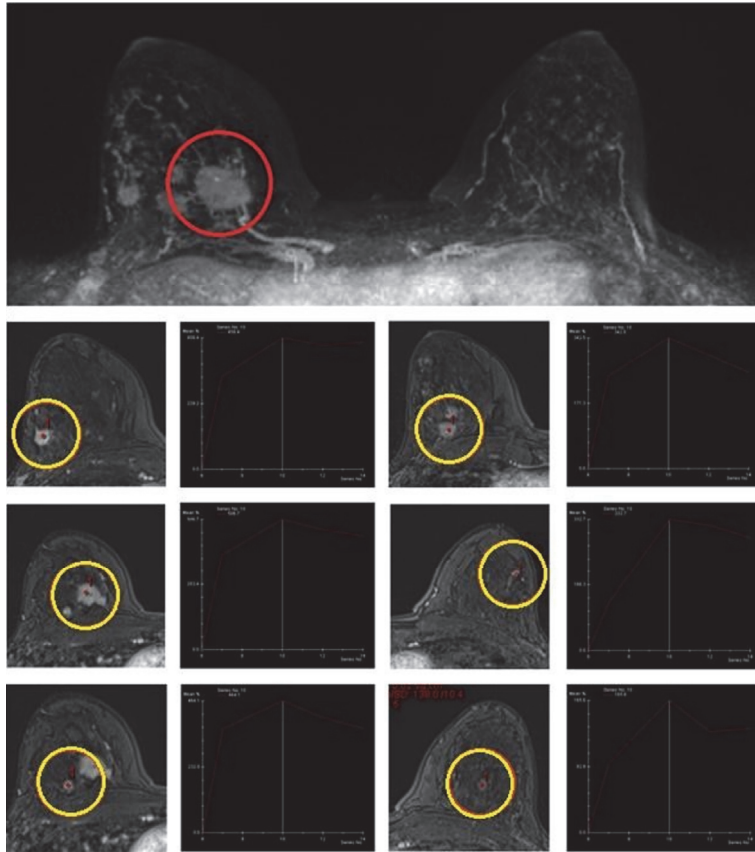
Index lesion (red circle; right SIQ, 27 mm), already documented with ultrasound. MRI leads to the detection of multifocal and multicentric disease, confirmed to US second look and biopsy (yellow circles: right SIQ, 6mm; right SEQ, 11mm; right CEQ, 10 mm; right CEQ dx, 11 mm; right CEQ dx, 5mm). Subcentimetric mass enhancement in the left breast resulted as negative to US second look. SEQ: Superior External Quadrant; SIQ: Superior Internal Quadrant; CEQ: Central External Quadrant.
